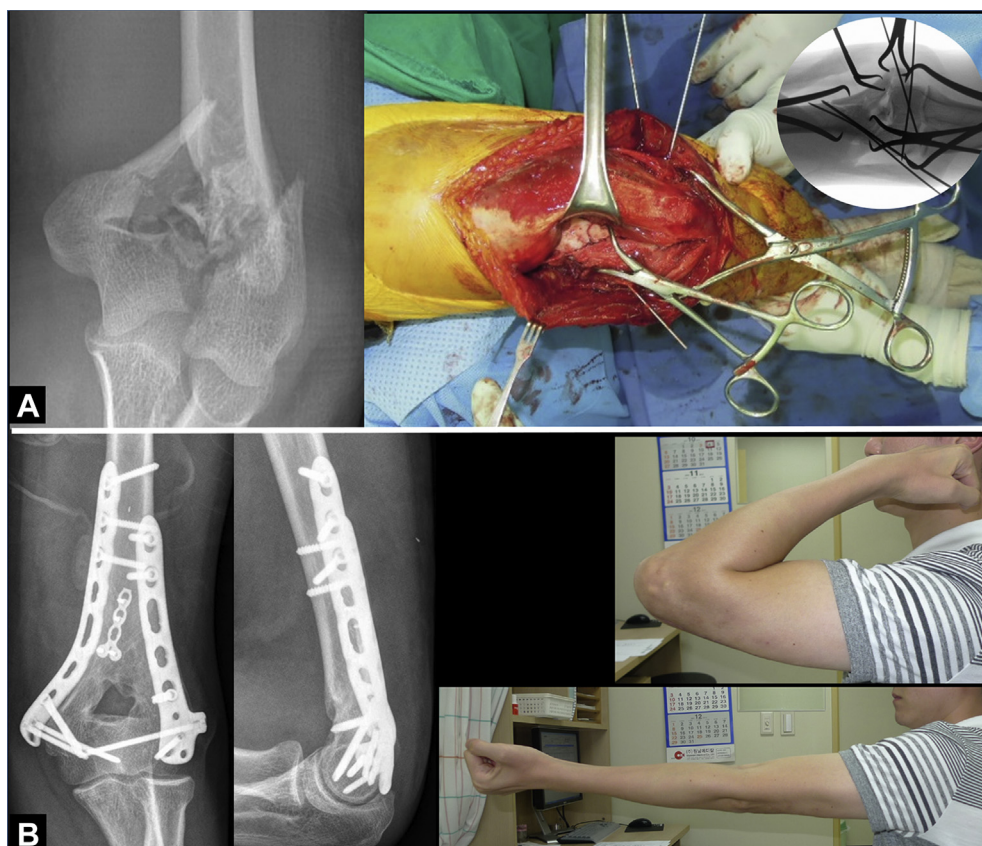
A 27-year-old male patient sustained an AO/Orthopaedic Trauma Association type 13C2 fracture. (A) A main intra-articular fracture (at zone 2) was reduced through the expanded paratricipital approach. (B) One-year follow-up radiographs demonstrate anatomic reduction of the articular surface without complications.
